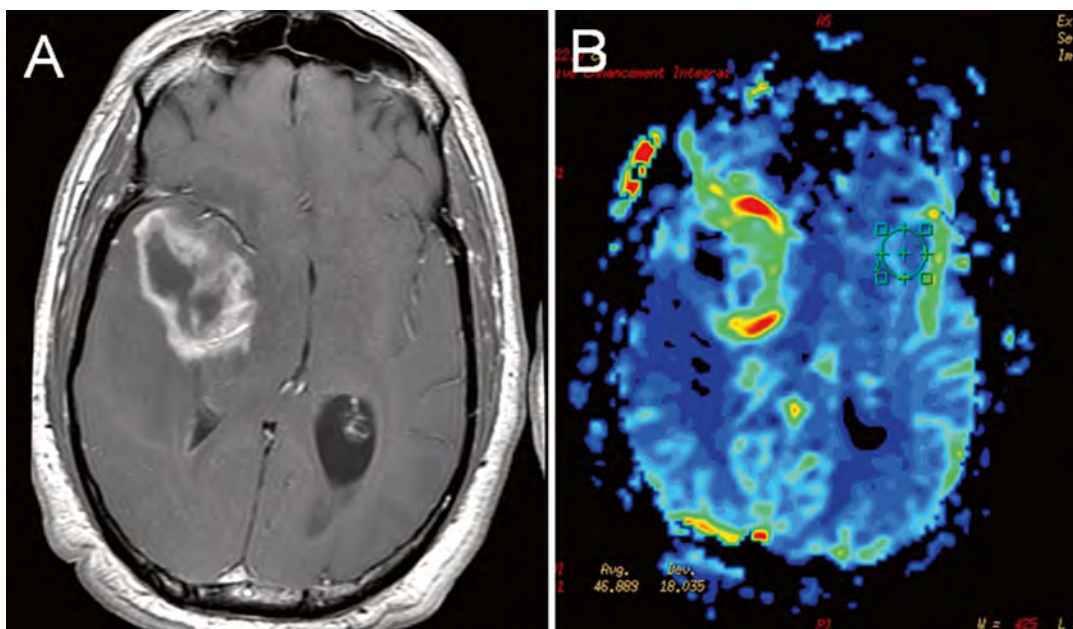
Axial T1 post-gadolinium (a) and perfusion (b) MRI showing areas of increased cerebral blood volume corresponding to areas of contrast enhancement within a right frontal lobe glioblastoma
